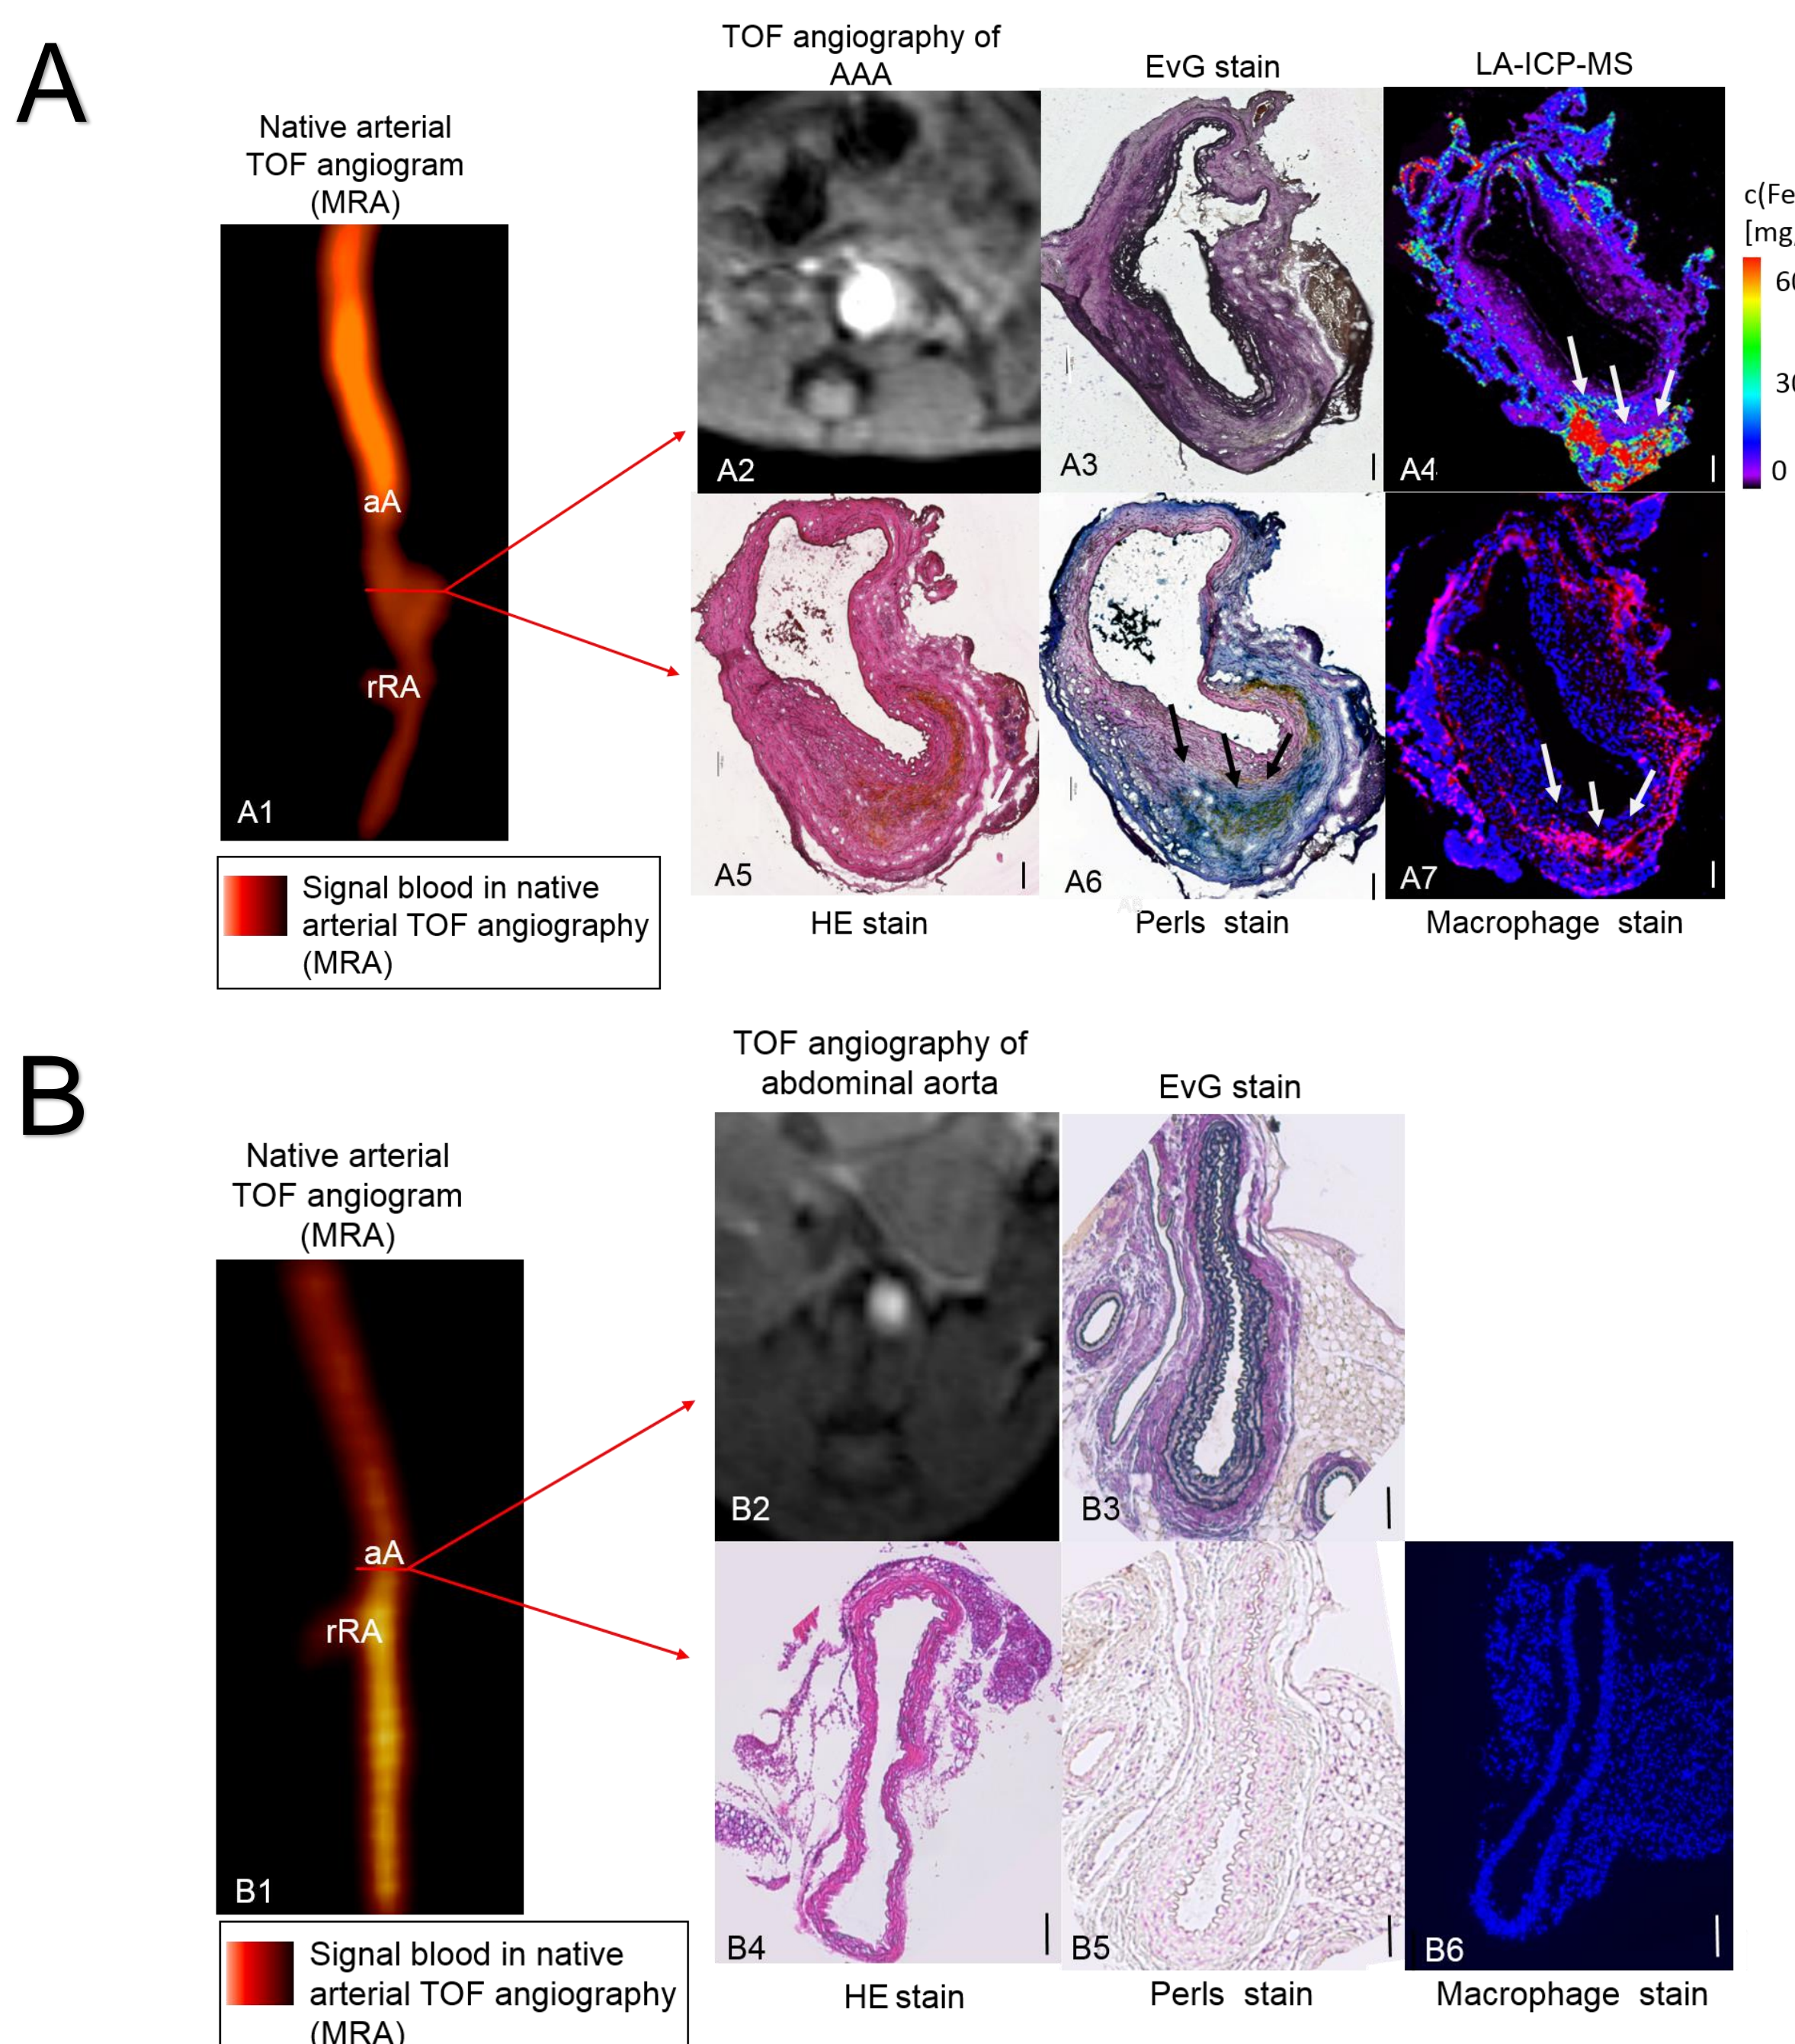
In vivo* MRI and *ex vivo* analysis of inflammatory-activity during the development of AAA
